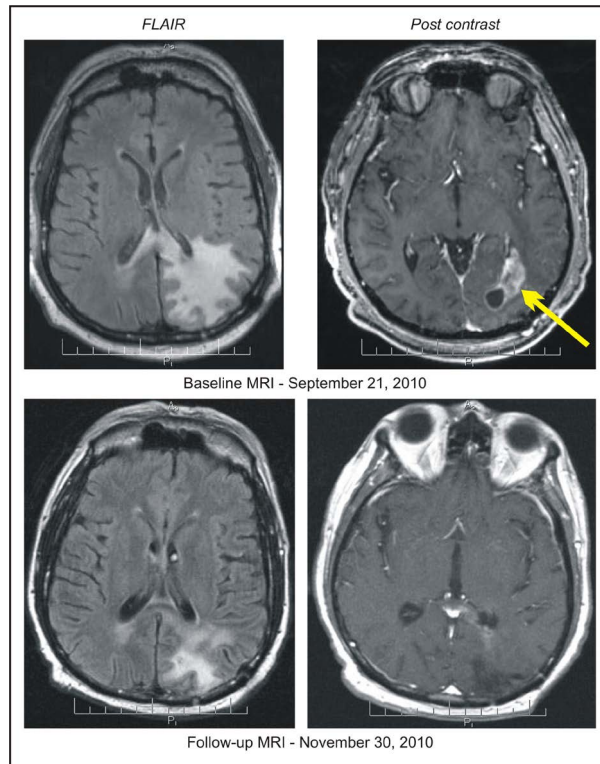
Patient 1, baseline and follow-up MRI of the head indicating partial response.
